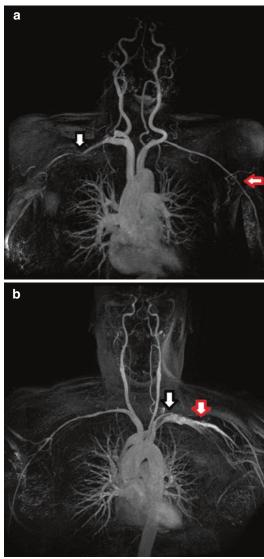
A 78-year-old female with Giant Cell arteritis presenting with upper arm claudication. MRI subclavians with runoffs reveal a short segment stenosis of the proximal third of the right subclavian artery (*black arrow*); furthermore, noted is the tapering of the left subclavian artery to the midaxillary artery (*red arrow*). (b) A 57-year-old female presenting with both cranial and large vessel vasculitis. MRI angiogram reveals a high-grade stenosis of the left subclavian, distal to the origin of the left vertebral artery (*black arrow*), and high-grade stenosis of the left subclavian at the junction of subclavian and axillary portions (*red arrow*)
